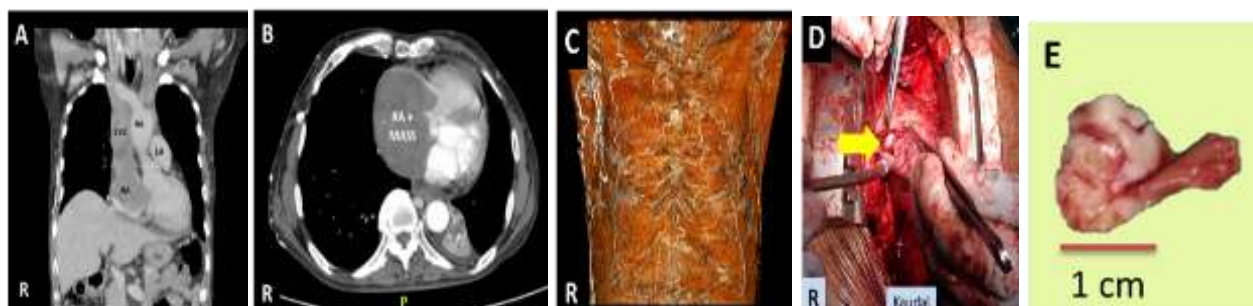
(A) and (B) CT scan of the coronal section shows an image of a mass filling the right atrium and superior-inferior vena cava which is confirmed by axial section. (C) From the 3D reconstruction, a collateral vein system is formed in the chest wall. (D) Intraoperative photos: excisional biopsy of the tumour (yellow arrow) taken directly from the right atrial chamber. (E) Macroscopic tissue tumour. SVC, superior vena cava; RA, right atrium; Ao, aorta; LA, left atrium
